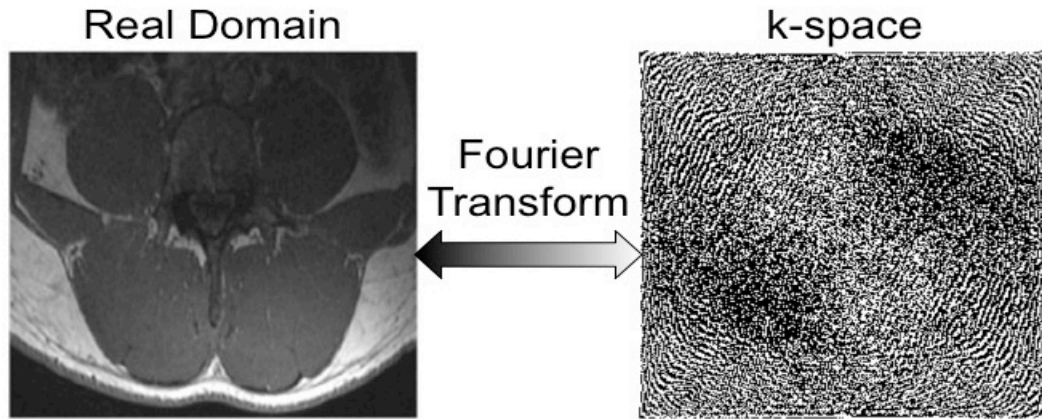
Sample MRI image in the real domain (left) and in the frequency domain (right).
